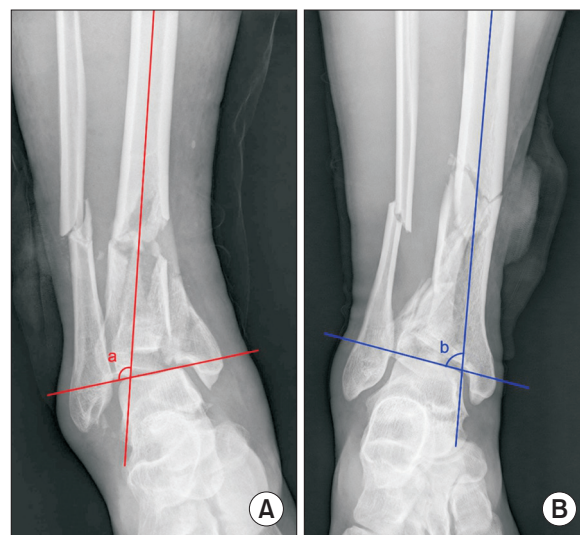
Anteroposterior radiographs of pilon fractures before intervention. Not all comminuted fibular fractures show valgus angulation. Not all transverse fibular fractures show varus angulation. (A) Radiograph showing varus angulation in a multifragment fibular fracture. a: lateral tibiotalar angle (LTTA) is 106.38°. (B) Radiograph showing valgus angulation in a simple fibular fracture. b: LTTA is 78.13°.
